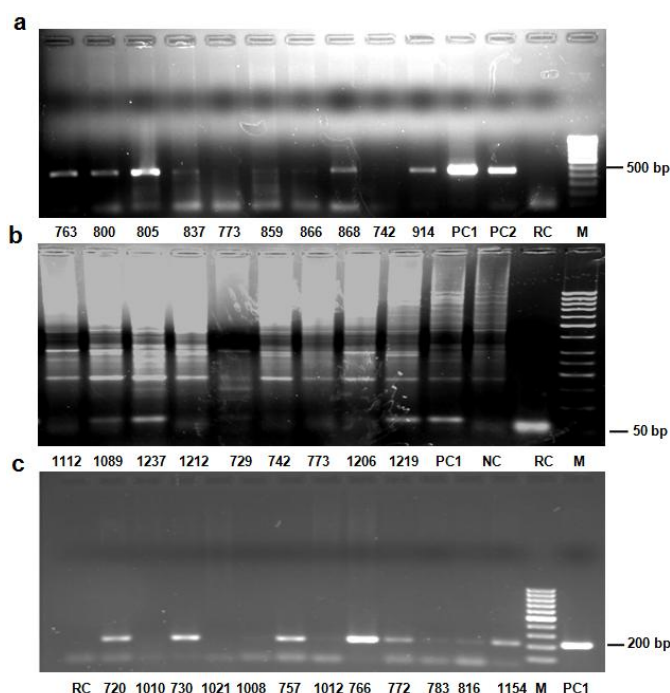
HPV positivity in cervical cancer biopsies by MY09/11 and SPF1/2 primer sets. 92 samples that were found to be HPV negative by GP5⁺/6⁺ primers were tested for DNA integrity by β -actin PCR. Samples that were positive for β -actin were further amplified by MY09/11 and resolved on a 1.5% agarose gel. A 450 bp band confirms presence of HPV (a). Also, the negative samples were checked by SPF1/2 primers and resolved on a 3% agarose gel wherein a 65 bp amplicon shows HPV positivity (b). HPV positive samples were checked for HPV16 and HPV18 infection by type- specific primers. 217 bp and 100 bp amplicon confirms presence of HPV16 and HPV18 respectively. 49 samples were positive for HPV16 (c). The sample names begin with 'CT'. PC= positive control, PC1= DNA from Hela cells, PC2= DNA from Caski cells, NC= negative control, DNA from C33A cells, RC=reagent control, M= molecular weight marker
